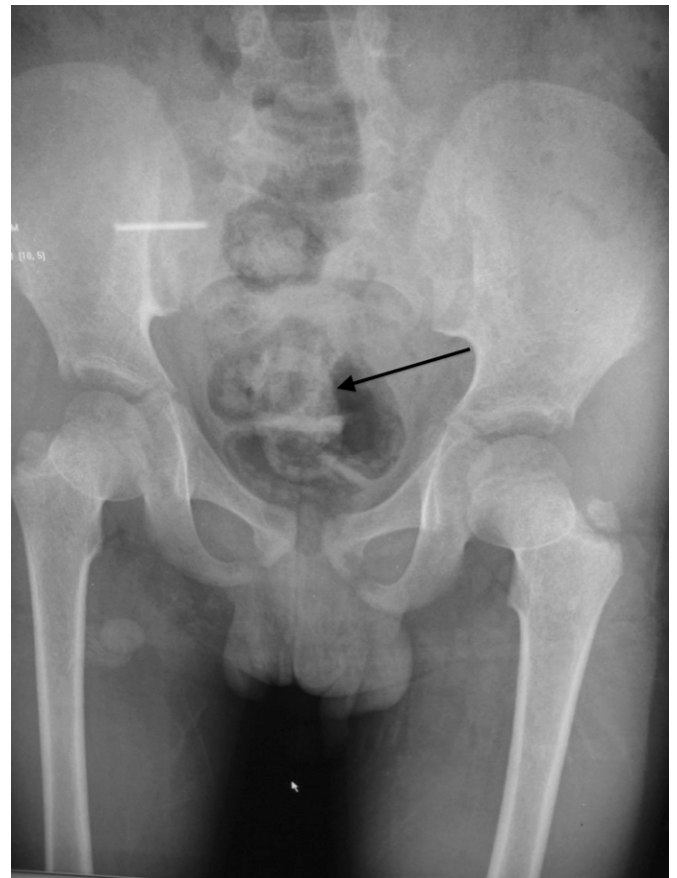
Plain abdominal radiograph demonstrating a large recurrent bladder stone (arrow) in 6-year-old boy.
